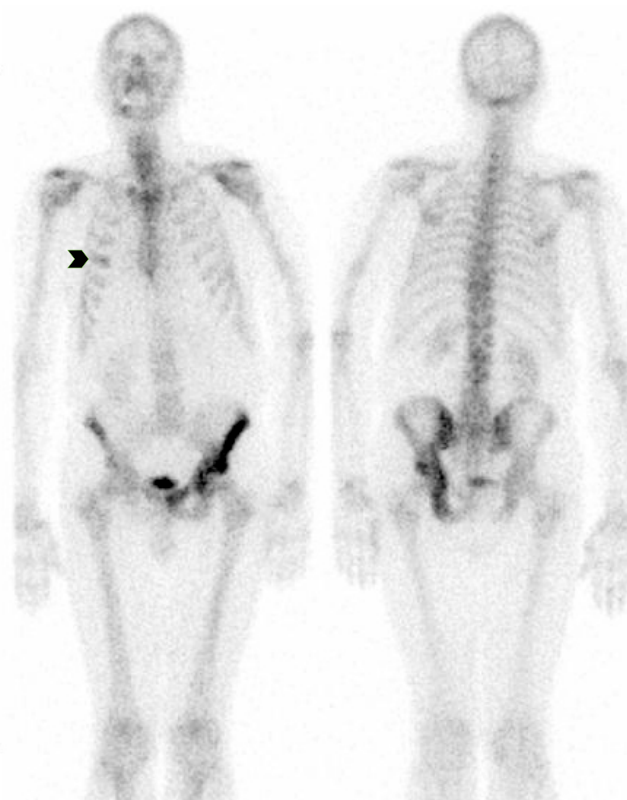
Whole-body bone scintigram shows diffuse low-grade tracer uptake in the left hemi-pelvis suggesting active Paget's disease. Faint focal uptake is present in the in right fourth rib (chevron). All other lesions have now disappeared
